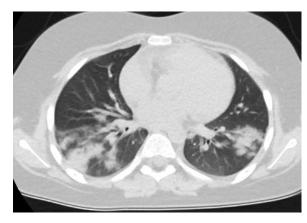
A section from thorax CT showed diffuse bilateral subpleural and peribronchial patchy ground-glass opacities involving multiple lung lobes.
